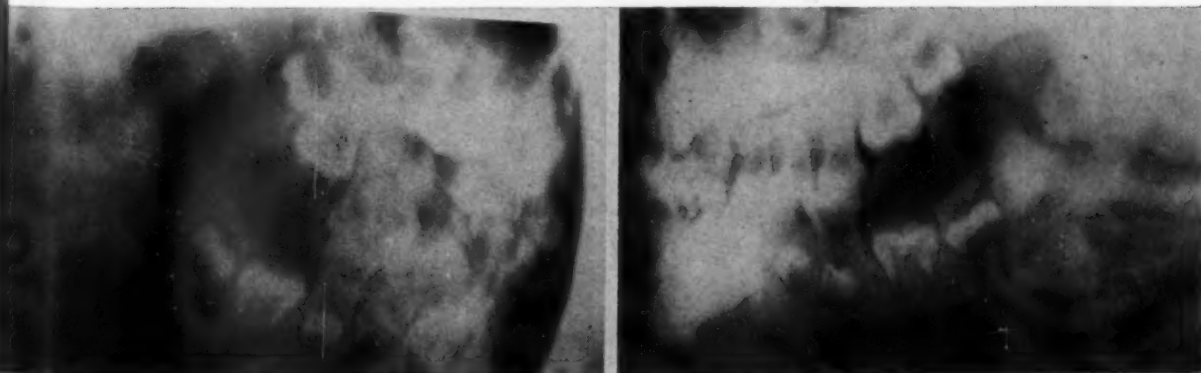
Lateral jaw roentgenograms showing noneruption of permanent first molars. NOTE: At the age of 9 years this patient shows a dental age of  $6\frac{1}{2}$  years.
